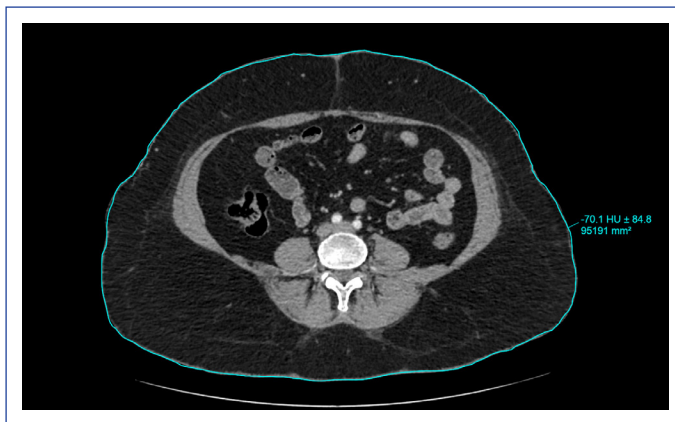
Evaluation of the waist circumference on a CT image, using both a line to approximate the skin contour and calculating in mm^2 .
